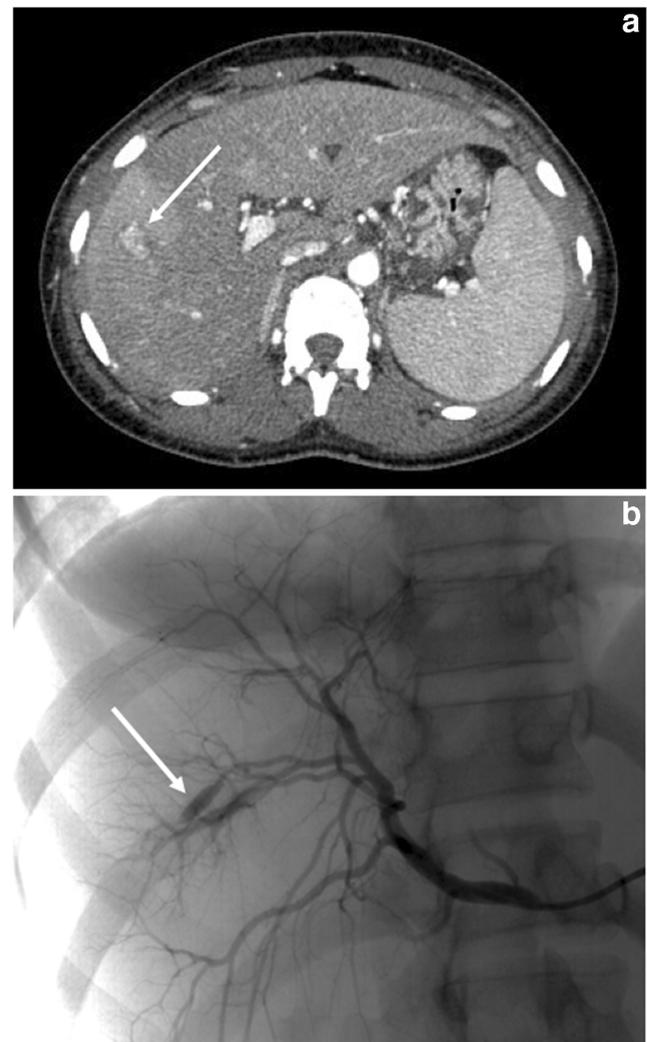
A 25-year-old female patient with acute hepatitis in the setting of co-infection with hepatitis B and C viruses. Pre-biopsy prothrombin time, activated partial thromboplastin time, platelet count, and serum creatinine level were 63% ($N = 70\text{--}100\%$), 1.19 ($N < 1.2$), 121 ($N = 150\text{--}400.10^9/L$), and $60 \mu\text{mol/L}$ ($N = 45\text{--}84 \mu\text{mol/L}$), respectively. One 16-gauge core biopsy was performed. The patient underwent abdominal US and CT 2 days after biopsy for abdominal pain and drop in hemoglobin. CT showed an arteriovenous shunt (arrow, a) and hemoperitoneum (not shown). The lesion was treated by intra-arterial embolization (arrow, b)
